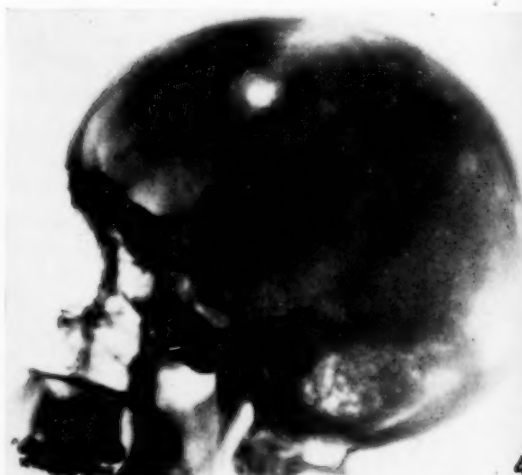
X-ray of skull on 16 November 1954.
